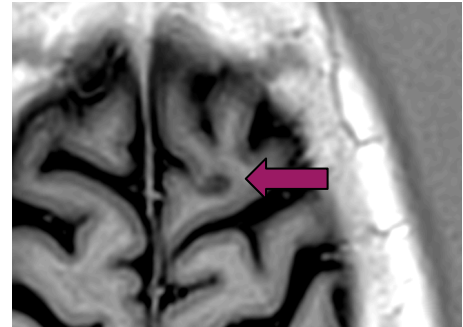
Image registration methods can aid the radiological readings by better utilizing our commonly acquired MRI data. One example is subtraction MRI where follow-up scans are overlaid on baseline scans to increase sensitivity for lesional change and atrophy.¹²⁶ Another application is FLAIR* where FLAIR sequences are registered to susceptibility weighted images, which increases the specificity of white matter abnormalities by identifying central venules in MS lesions.¹²⁷
